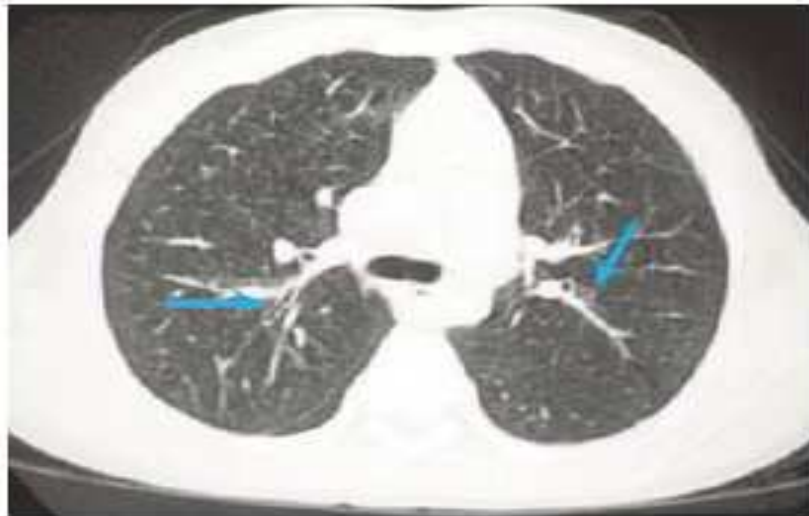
Inspiratory chest CT demonstrating mild peribronchial thickening (left arrow) and minimal airway dilatation (right arrow) in an 11-year-old boy.
